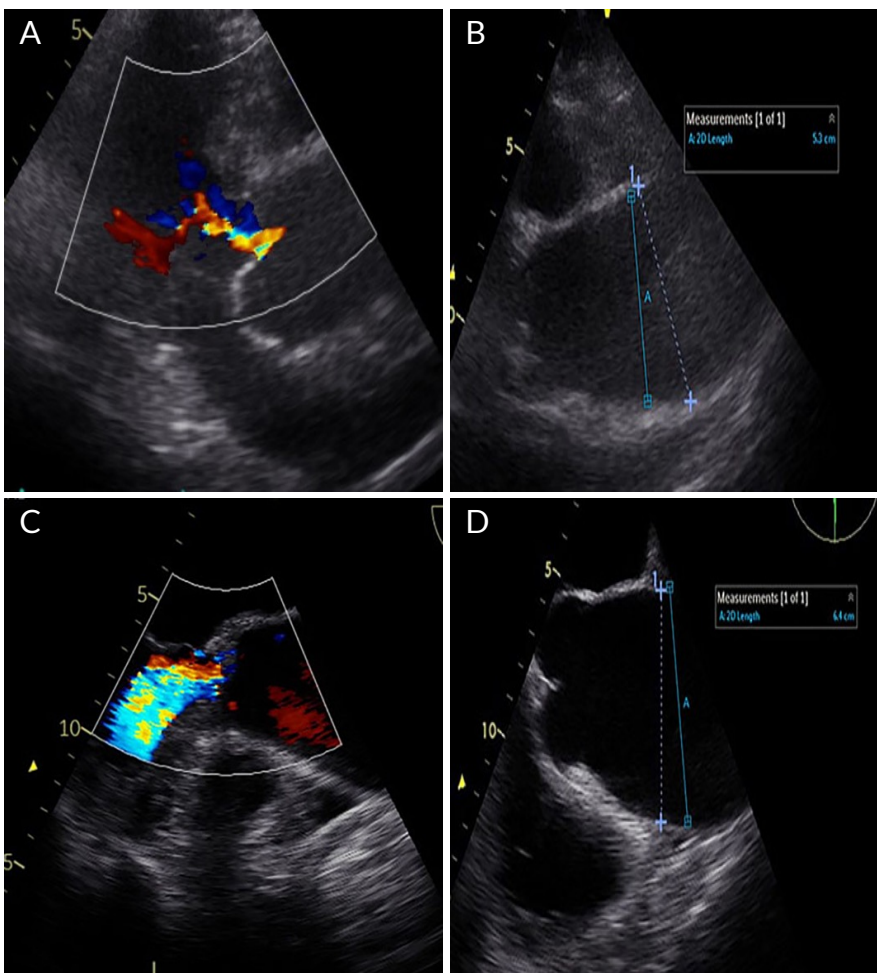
A) Transthoracic parasternal long axis view demonstrating mild central aortic incompetence with dilated aortic root (13 months); B) Transthoracic parasternal long axis view demonstrating significantly dilated aortic root and ascending aorta (13 months); C) Long axis view transoesophageal echo demonstrating worsening aortic root dilation with moderate to severe aortic incompetence (20 months); D) Transoesophageal echo demonstrating rapid progression of ascending aortic aneurysm (20 months).
